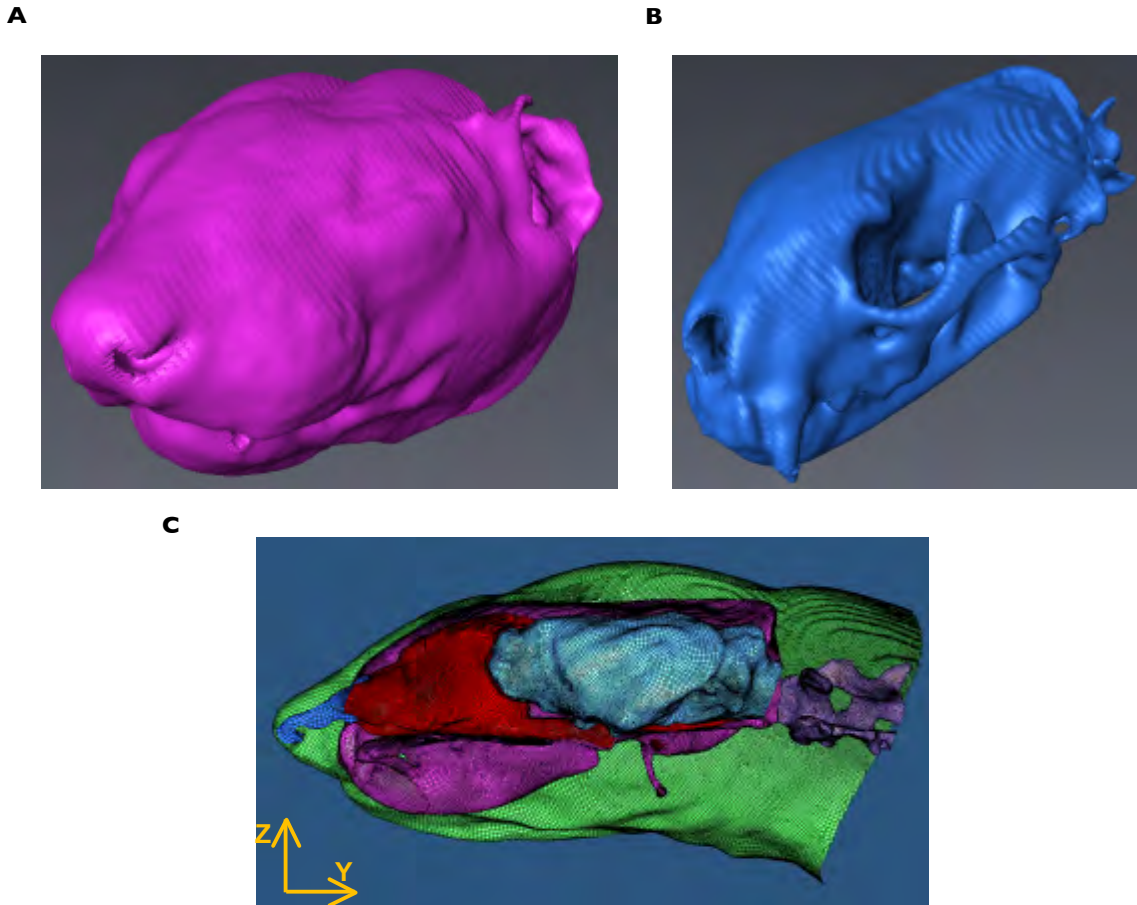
Isosurface representations of segmented tissues of the ferret CT for exterior soft tissue (A) and skull (B). A medial view of the surface meshes for the interfaces of various tissue types generated from the segmented CT (C).
